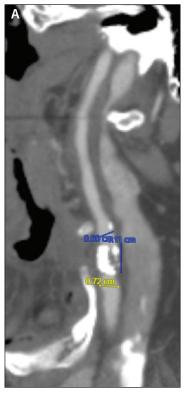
CTA demonstrating severe, complex, calcified, near-occlusive disease of the distal left CCA (A). MRA demonstrating severe, high-grade, distal left CCA stenosis with subtotal occlusions of the left ECA and ICA (B).
